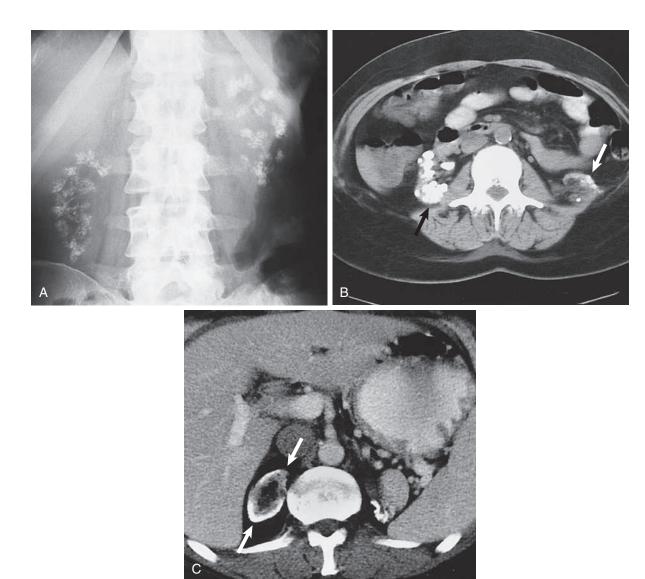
Nephrocalcinosis. (A) Plain x-ray film shows bilateral medullary nephrocalcinosis in a patient with distal renal tubular acidosis. (B) Noncontrast CT scan in a patient with hereditary oxalosis and dense bilateral renal calcification *(arrows)*. The left kidney is atrophic. (C) Noncontrast CT scan shows cortical nephrocalcinosis in the right kidney *(arrows)* after cortical necrosis.
